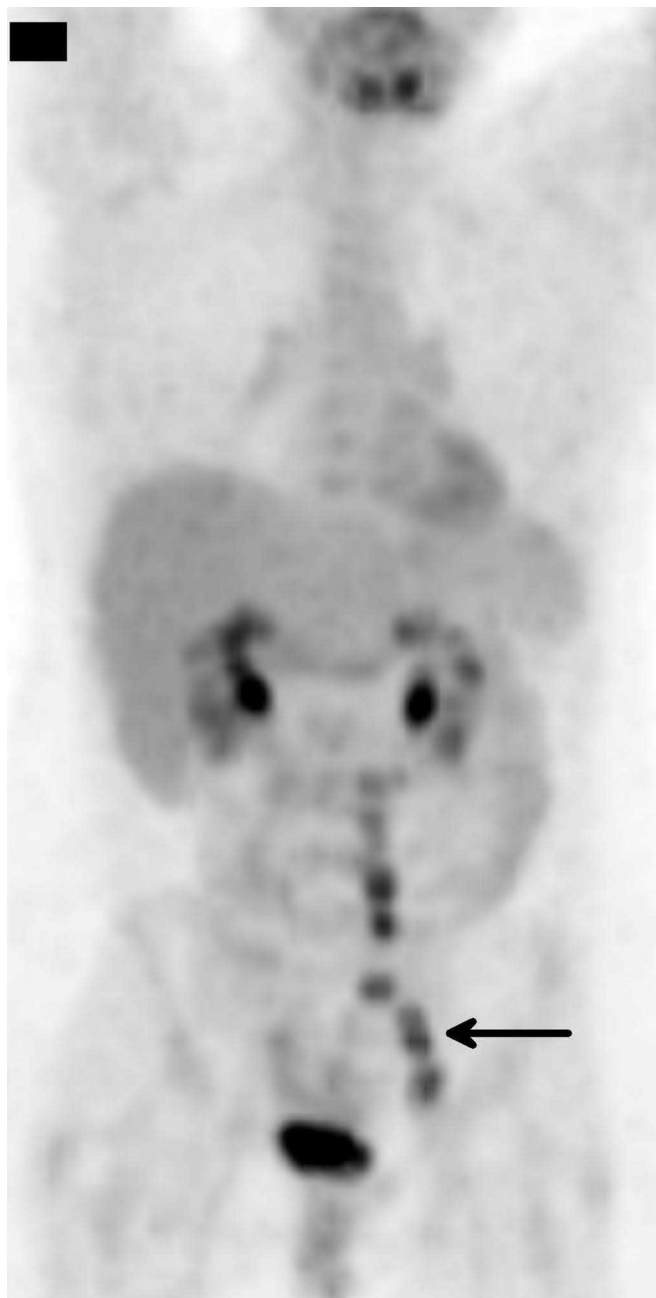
Positron Emission Tomography (PET) image demonstrating intense F-18 Fluorodeoxyglucose (FDG) uptake by uterine cervix, lower uterine segment, left iliac lymph nodes (arrow), and L2 retroperitoneal lymph nodes.
